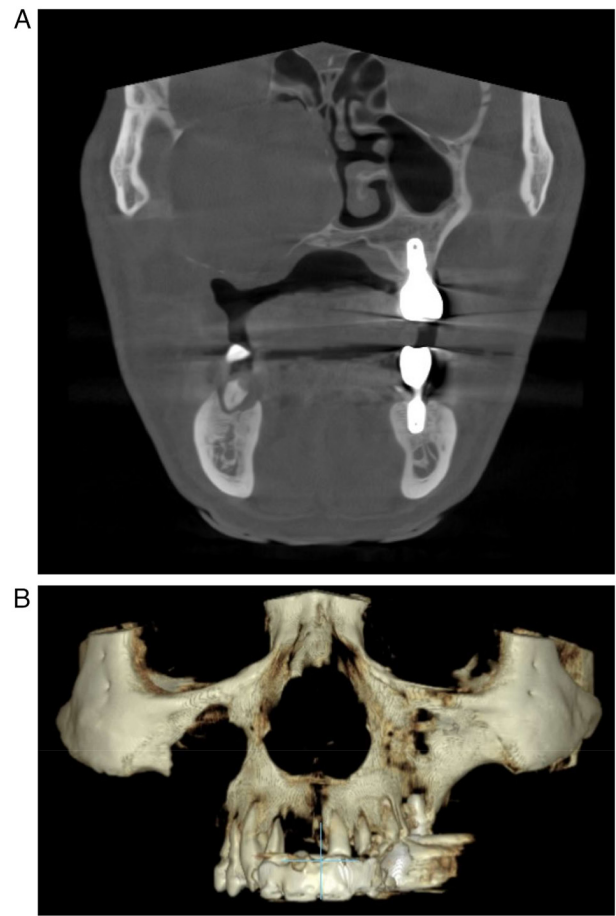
Preoperative cone-beam computed tomography images showing a large, expansile mass with smooth margins. The lesion is radiolucent and lacks septa or a fluid level. (A) Coronal view. (B) Three-dimensional reconstructed image.
